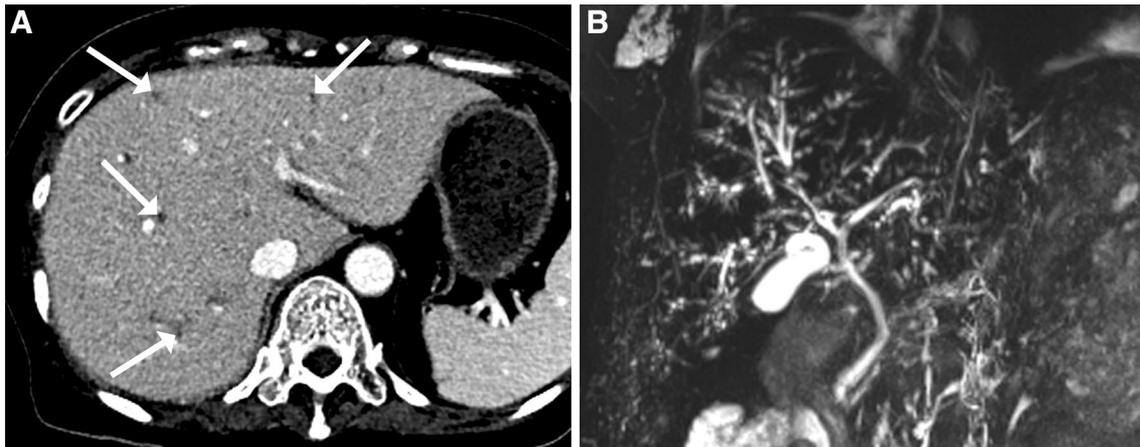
A 54-year-old woman who underwent bilateral lung transplantation for bronchiolitis obliterans. A CT obtained 63 days after lung transplantation shows multifocal mild intrahepatic ductal dilatation (arrows). Bile duct wall thickening is not observed. B Two-dimensional MRCP
